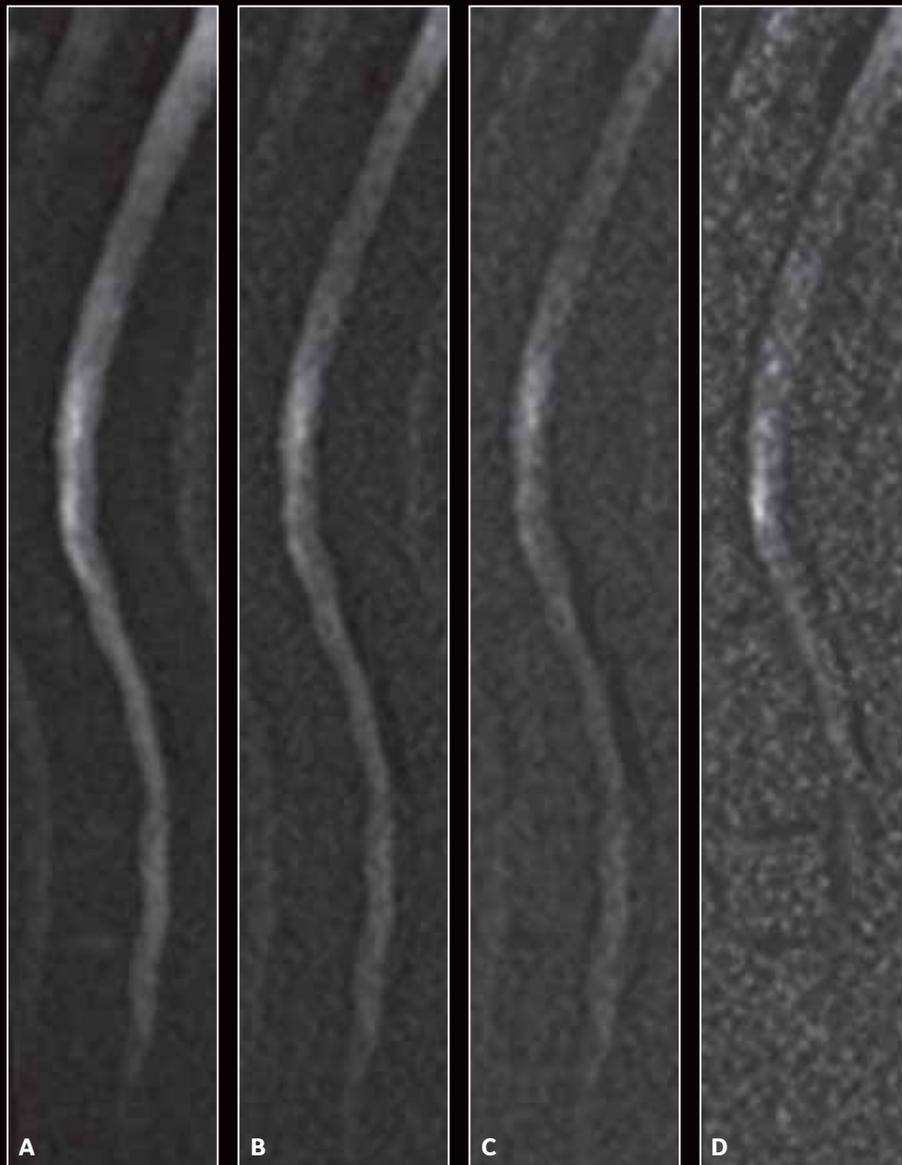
Synthetic DWI at b-values of (A) 800, (B) 1000, (C) 1400, (D) 2000. B-values of 800-1000 provide improved contrast and preserved spinal cord anatomy.
